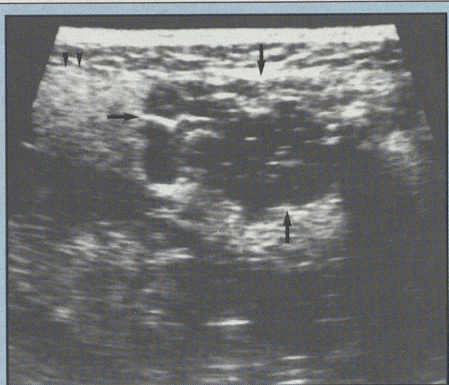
Transverse sonogram of the submandibular area showing an ill-defined, hypoechoic, heterogeneous mass (arrows) with small cystic spaces adjacent to the submandibular gland (arrowheads).
